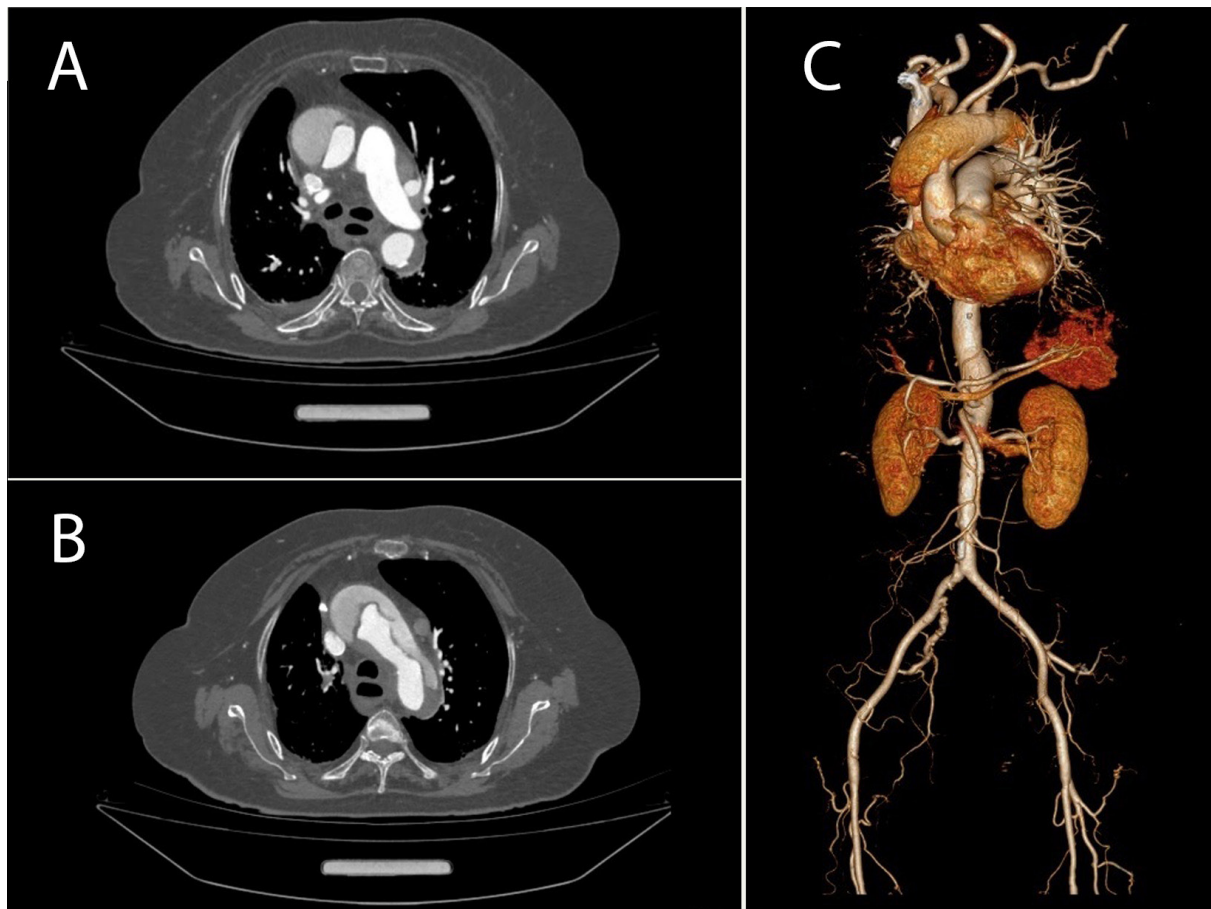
computed tomographic angiography (CTA) of the octogenarian with ATAAD. (A) Acute dissection can be observed both in the ascending aorta and the descending aorta. (B) The site of primary entry was found at the aortic arch (yellow arrow). (C) 3D reconstruction of preoperative CTA showed the aortic dissection extended from the ascending aorta to the descending aorta.
